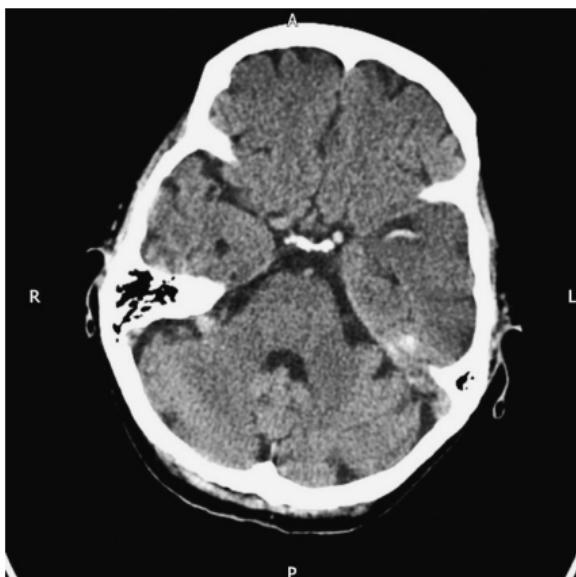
Hyperdense left middle cerebral artery seen on CT scan as an early sign of acute stroke.
